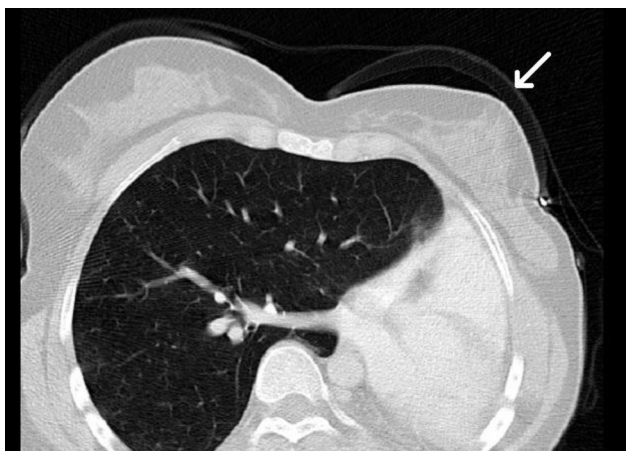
Axial computed tomography (CT) image of the thorax obtained at the level of the pulmonary arteries. Note absence of the left pulmonary artery. The right pulmonary artery is normal.
